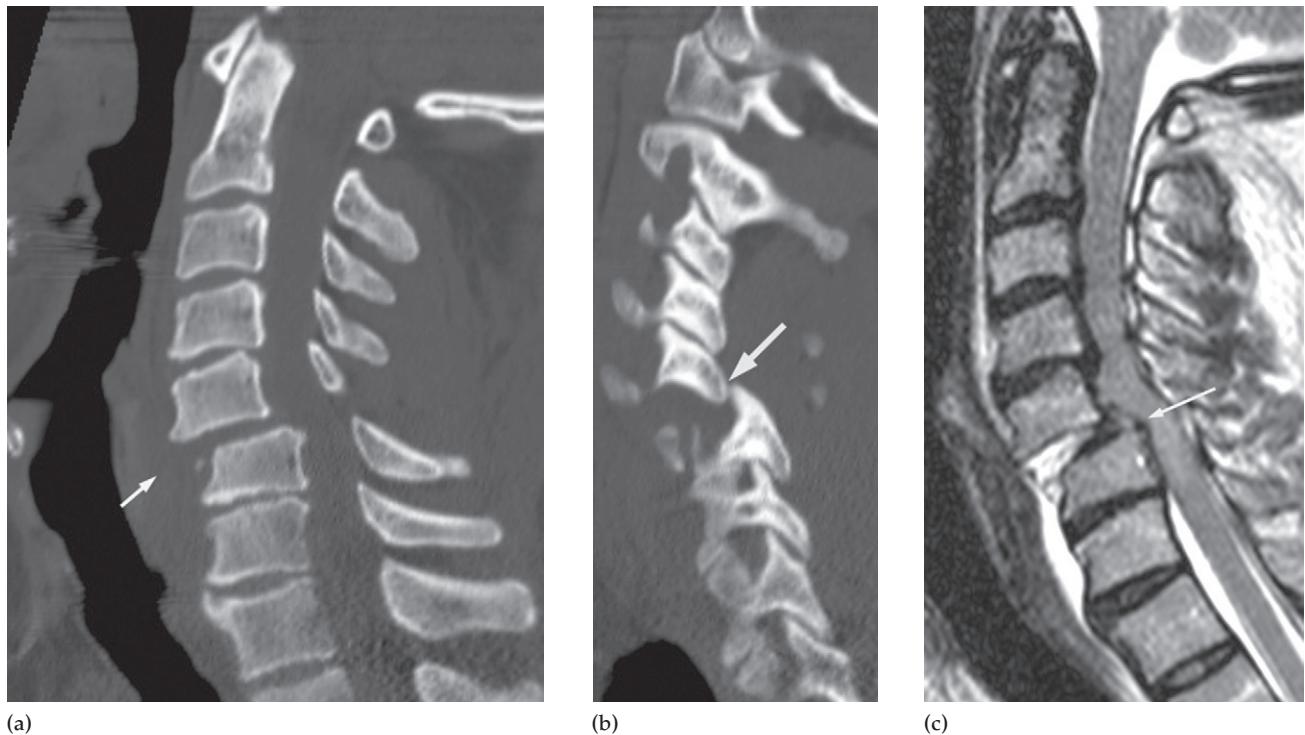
Cervical spine injury. (a) On this midline CT scan there is a step in the alignment at the C5/C6 level. Soft tissue swelling is seen anteriorly at this level (arrow). (b) A section more laterally showing facet dislocation with overlap of the facets (arrow). (c) T2-weighted MRI showing injury to the intervertebral disc and displacement at the C6 level which has caused some spinal cord compression and oedema (arrow). High signal haemorrhage is seen anteriorly.
